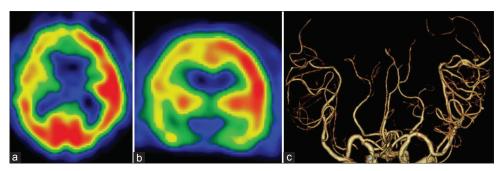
(a and b) Axial section and coronal section of single-photon emission CT showed hyperperfusion of the left hemisphere day after surgery, (c) CT angiography showing marked left MCA dilation the day after surgery.
